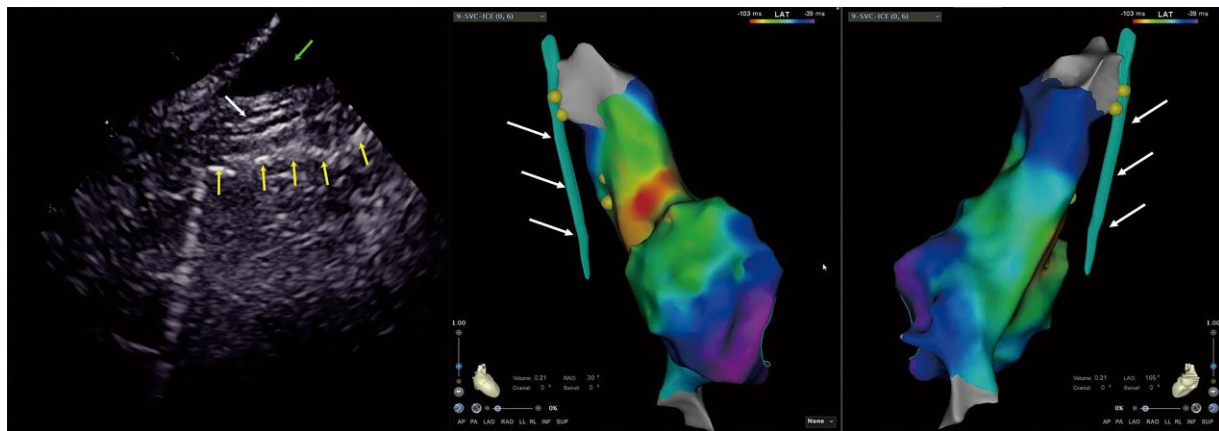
The anatomical relationship of the right phrenic nerve (RPN) and the superior vena cava (SVC). The distance between the RPN and the SVC is increased from the craniocaudal direction in the 3D activation map of the right atrium (RA) and SVC in right anterior oblique (RAO) 30° and left anterior oblique (LAO) 165° views. Left image: the RPN imaging under intracardiac echocardiography (ICE). The middle arrow indicates the RPN, the bottom row of arrows indicate the mediastinal pleura, and the up row of arrow indicates the pericardial fluid. Middle and right images: the same patient's 3D activation maps of the RA and SVC in RAO 30° and LAO 165° view. The arrows indicate the RPN integrated into the electroanatomical shell.
